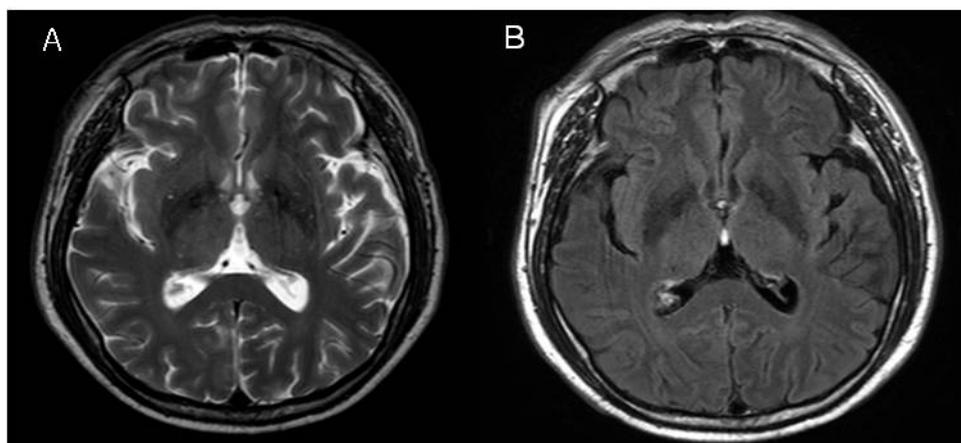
Brain MRIs of the patient. Axial T2-weight image (A) and FLAIR image (B) show no definite abnormality in basal ganglia.
